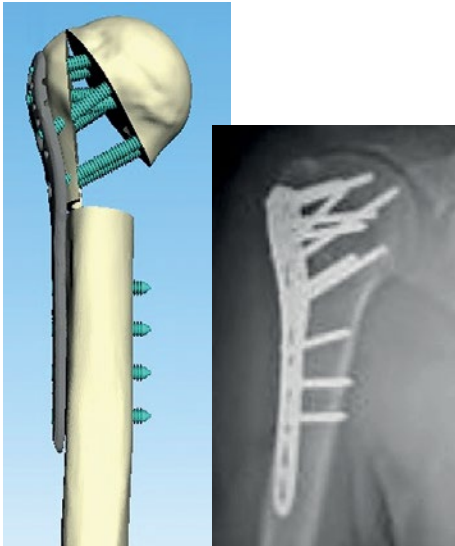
Model and x-ray of humerus with implanted bone plate
